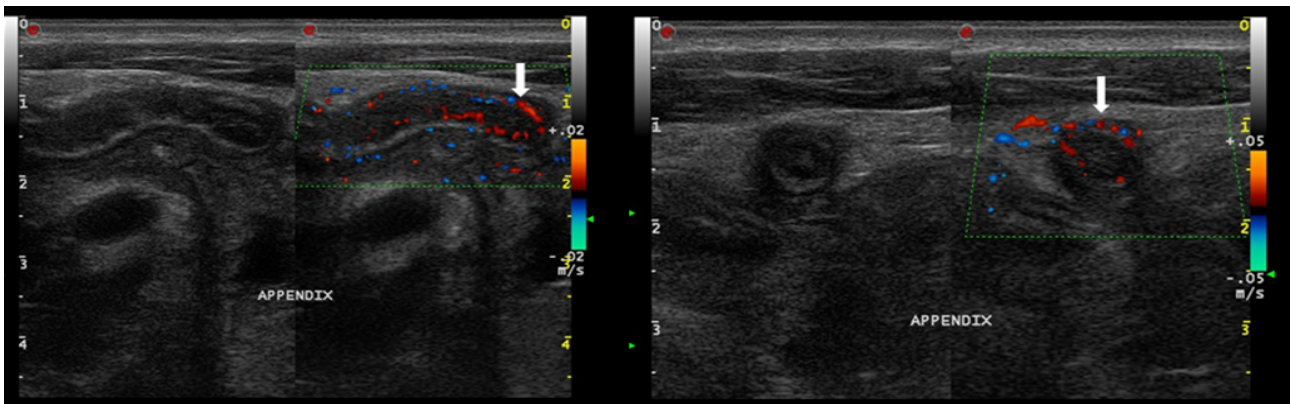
Acute appendicitis: Doppler imaging showing increased vascularity of the walls in axial and longitudinal views
